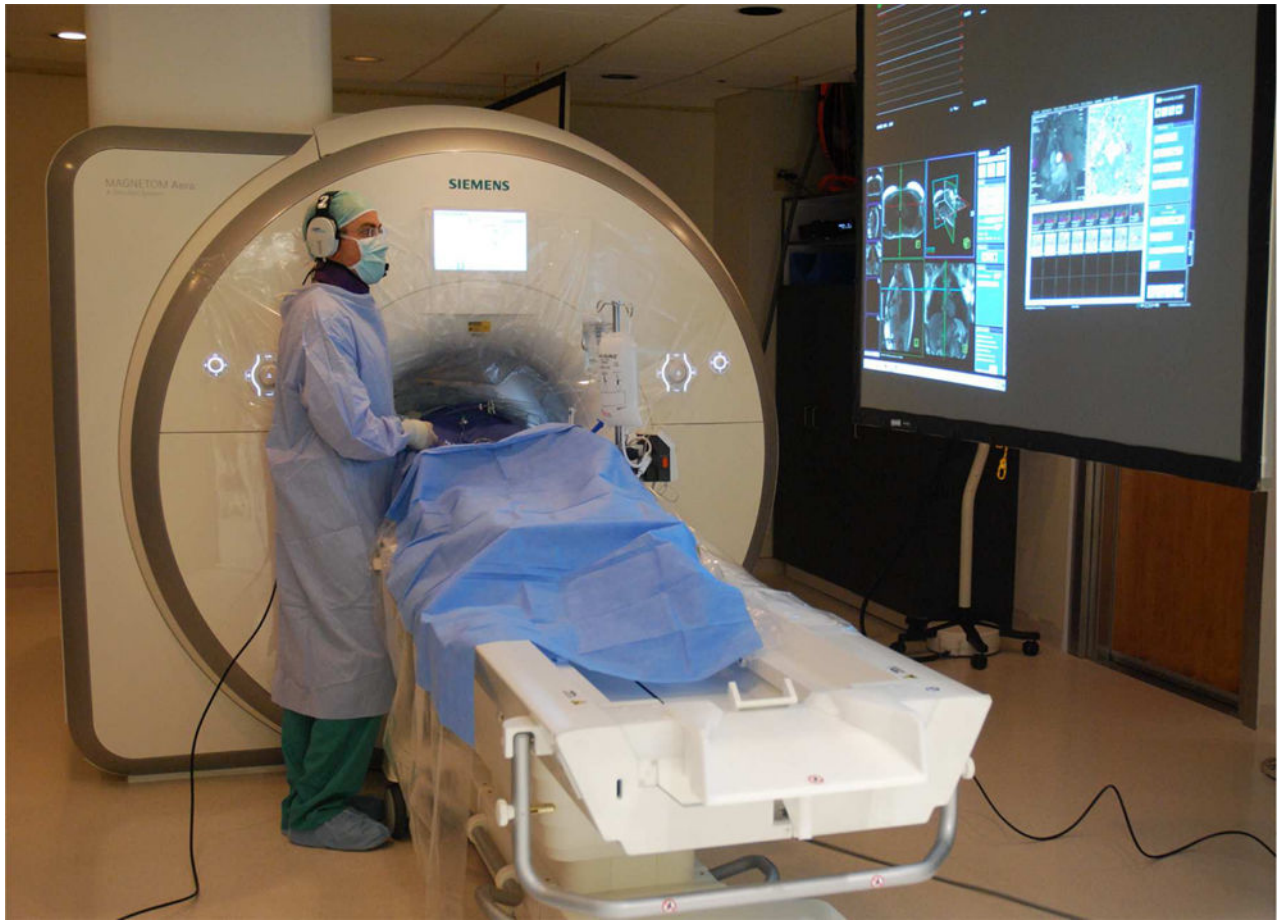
Components of an interventional MRI suite
